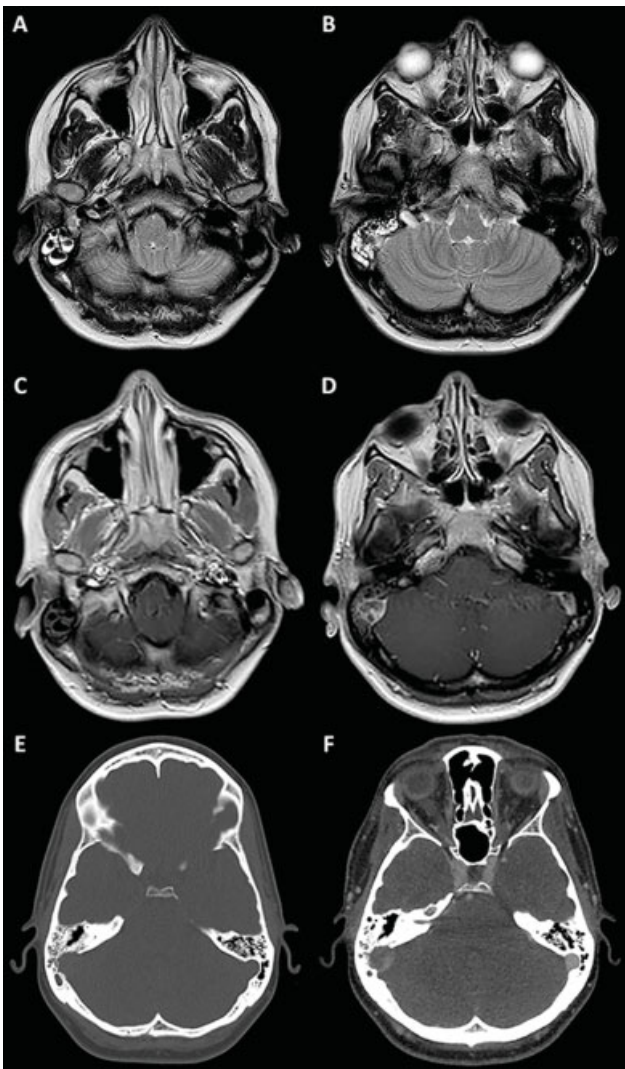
Initial MRI and CT:
